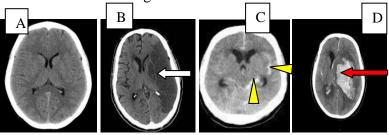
axial CT images showing (A), normal brain, (B) Ischemic brain, (C) subarachnoid haemorrhage and (D) intracerebral haemorrhage
